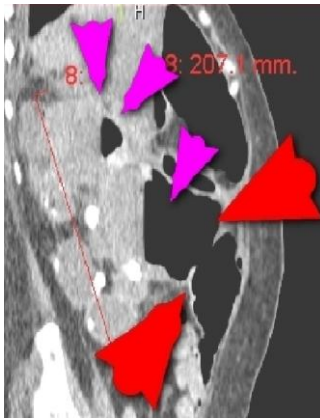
A sagittal CT image showed markedly enlarged kidney (around 20.7 cm in craniocaudal length), small left intra-renal gas (pink arrowheads) and the left reno-colonic fistula (red arrowheads).
